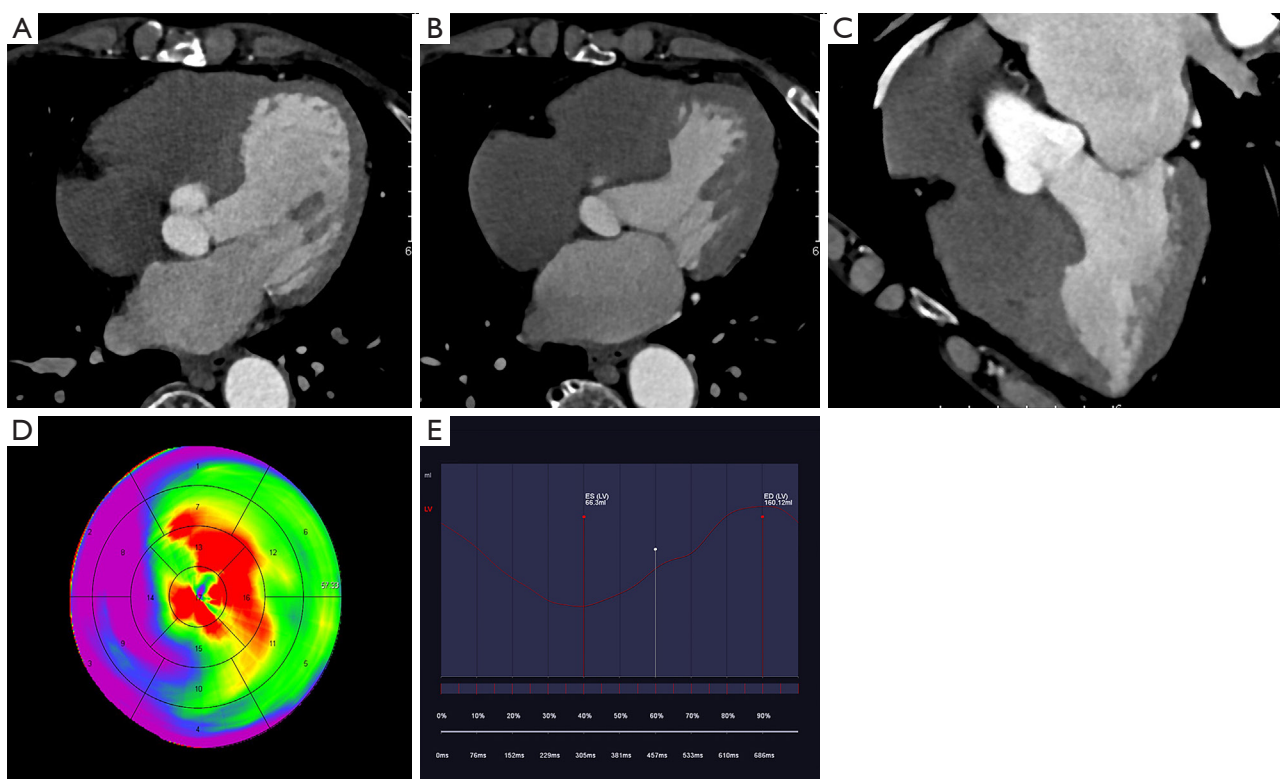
Cardiac computed tomography scan of a patient with HFpEF. (A) End-diastolic four-chamber view; (B) end-systolic four-chamber view; (C) left ventricular long axis; (D) ventricular wall thickening view; (E) ventricular volume view. HFpEF, heart failure patients with preserved ejection fraction.
